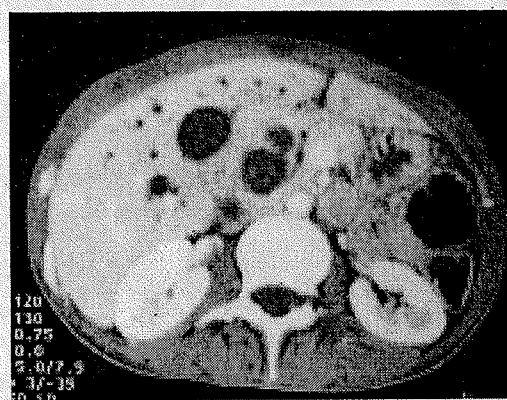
(b) : CT section, at a more caudal level, shows the double duct sign (dilated CBD & MPD).
